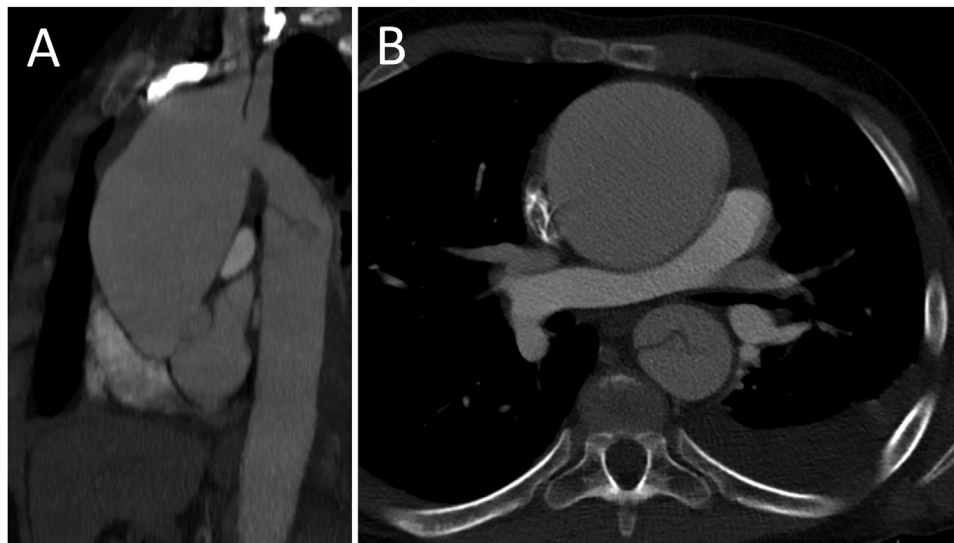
(A) Sagittal and (B) axial images of a computed tomography scan of a 14-year-old boy with a large ascending aortic aneurysm and a type B aortic dissection related to a pathogenic variant in ACTA2.
